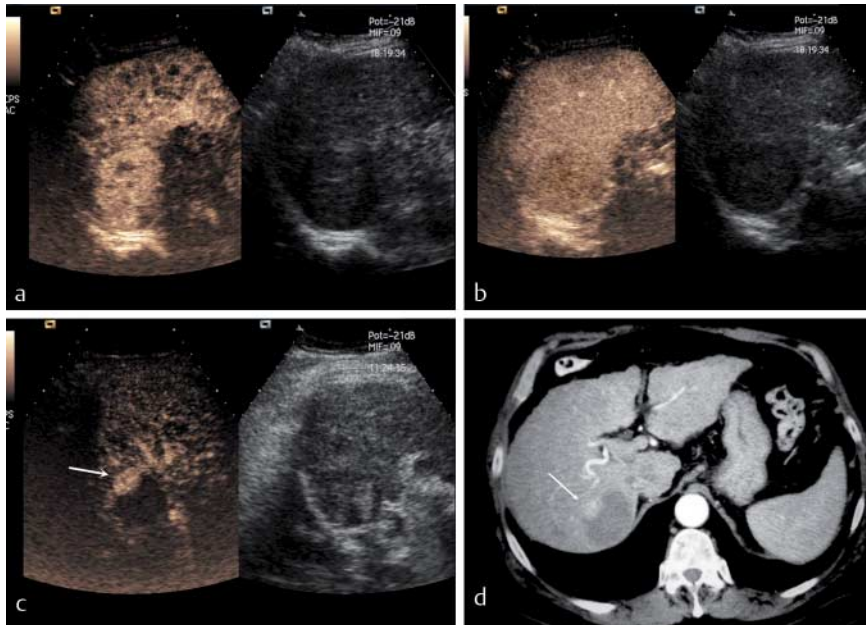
a Pre-RF ablation: CEUS shows an hypervascular hepatic lesion during the arterial phase. b Pre-RF ablation: almost complete wash-out during the portal phase. c Post-RF treatment: arterial phase of CEUS shows the presence of local recurrence (arrow). d After RF treatment: arterial phase of CT (arrow indicates recurrence).
